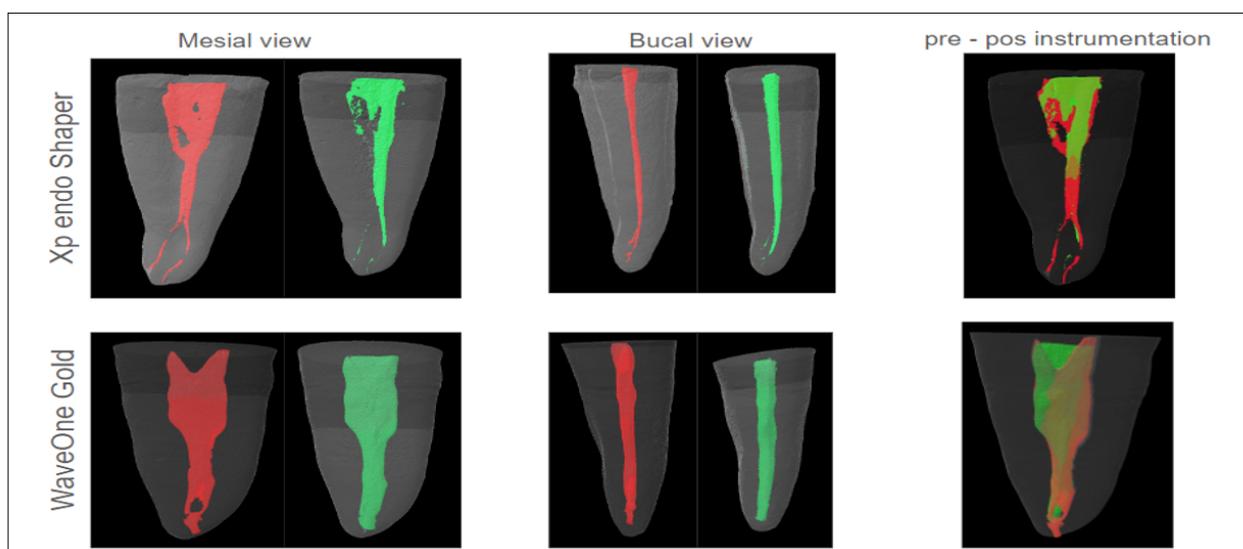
Microcomputed tomography images in mesial view, buccal view and overlay taken before (red) and after (green) the use of rotary and reciprocating instruments reveal areas that were not prepared (red).
